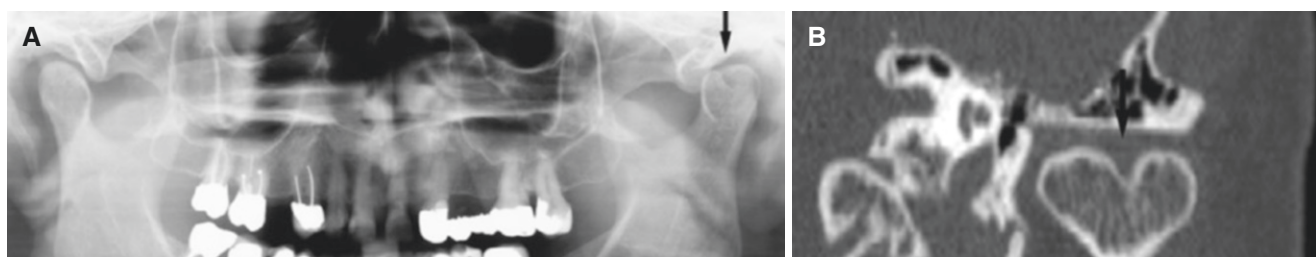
Bifid condyle; unilateral. (A) Panoramic view shows abnormal left condyle (*arrow*) as an incidental finding. (B) Oblique coronal CT image shows split condyle (*arrow*) but otherwise normal bone structure
